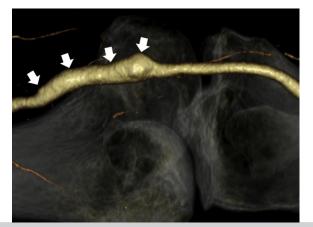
Computed tomography angiography image showing the postoperative popliteal artery (*arrows*) at the right knee. The flow in the popliteal artery recovered with bypass grafting using the saphenous vein.
